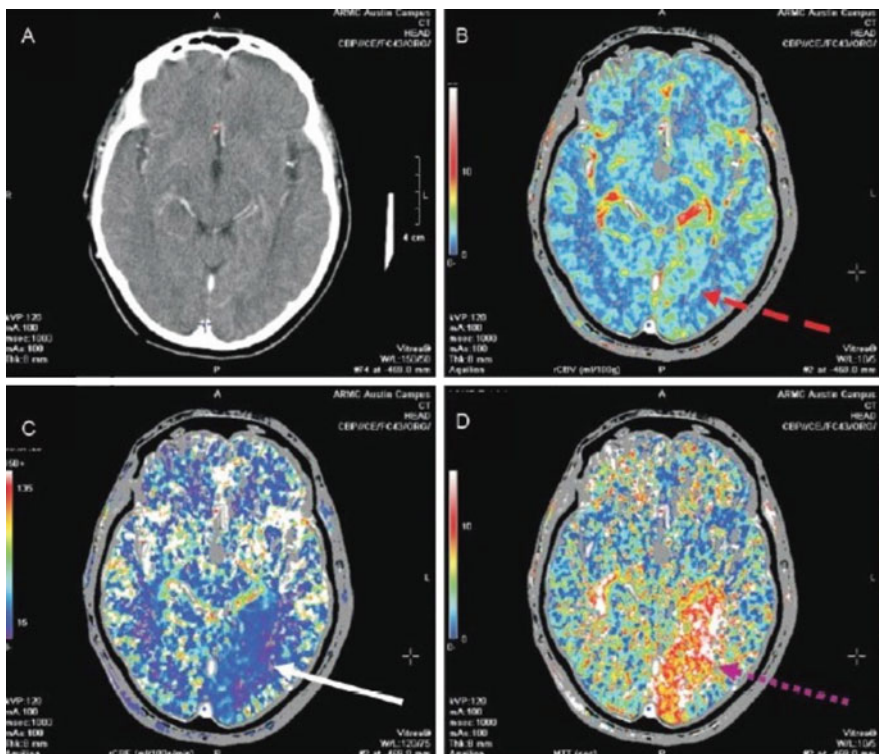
CT Perfusion: noncontrast-enhanced CT (NECT) and CT perfusion maps of a patient presenting within 1 h of stroke onset. NECT was normal and CT perfusion revealed large penumbra in form of increased mean transit time (MTT), normal cerebral blood volume (CBV), and reduced cerebral blood flow (CBF). (a) Normal NECT. (b) CT perfusion showing normal CBV. (c) CT perfusion showing reduced CBF. (d) CT perfusion showing increased MTT. Taken from Dhamija and Donnan (2008). Available at the website of the journal *Annals of Indian Academy of Neurology*. http://www.annalsofian.org/temp/AnnIndianAcadNeurol11512-4945421_134414.pdf
